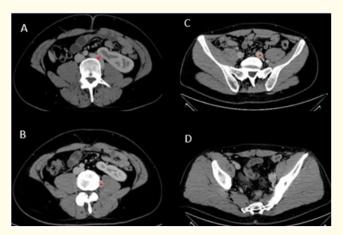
Axial CT images. Image A shows the aorto-iliac bifurcation, with the left common iliac artery turning at a 90 degree angle to the aorta postero-laterally (\*). Image B shows the left common iliac artery traveling in a plane lateral to the L4 Vertebral body and medial to the psoas muscle. Image C shows the aberrant left common iliac traveling in a retro-psoas plane. Image D shows the aberrant left retro-psoas iliac artery giving off a smaller caliber branch-off artery.
